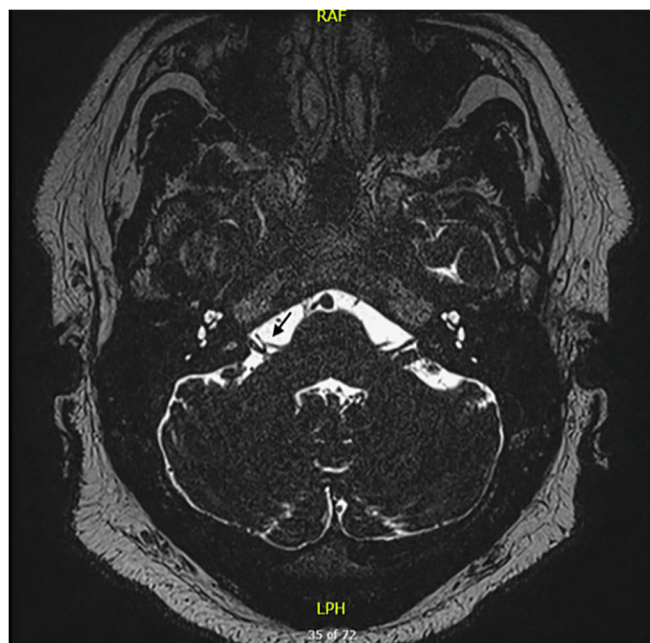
Axial T2 weighted magnetic resonance image demonstrating AICA compression at the root entry zone of the facial nerve (arrow).
